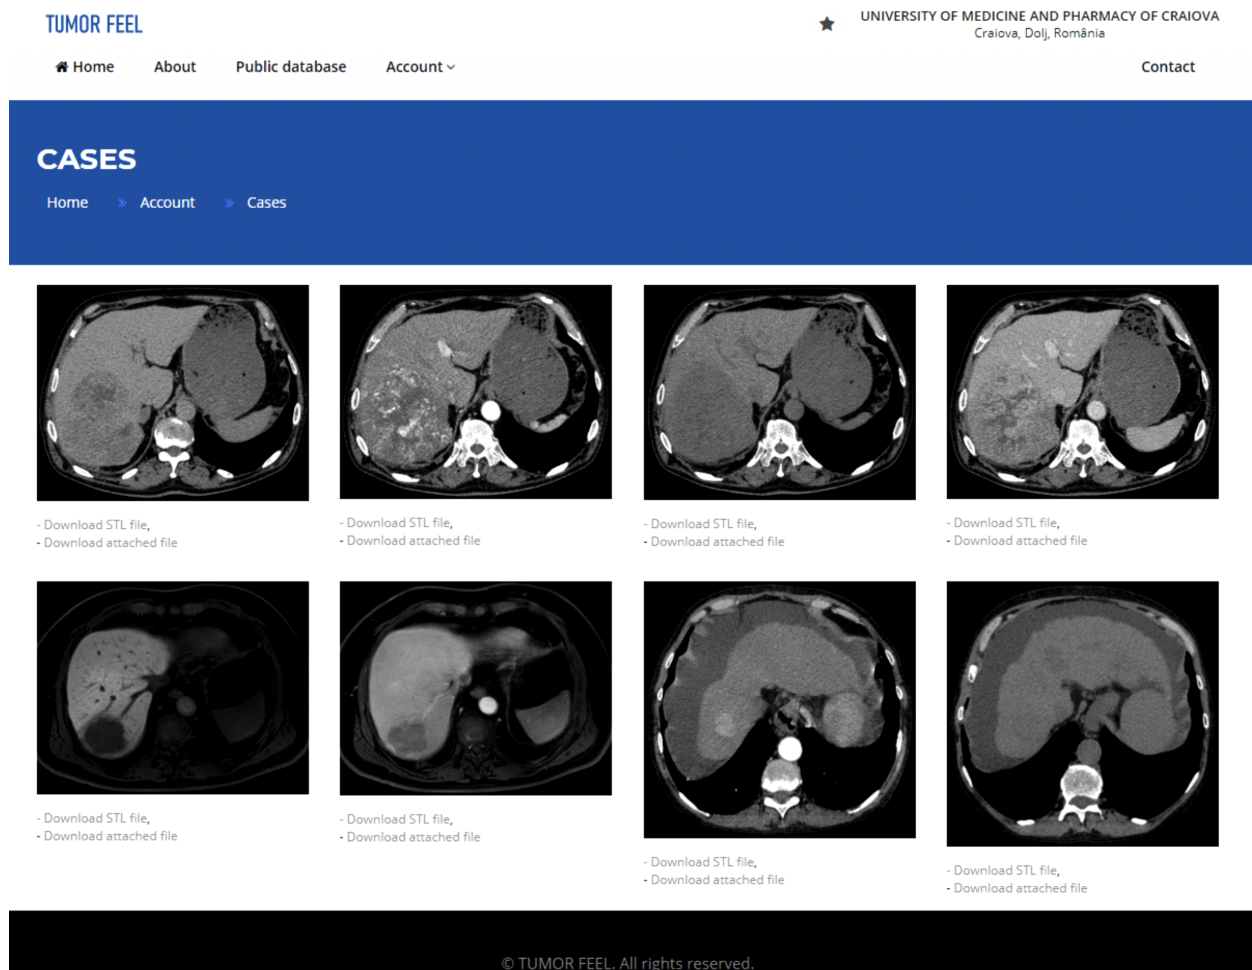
The main screen of the web interface, with CT or MRI images representative for each case. The interface can be accessed after secure login and only designated medical doctors can retrieve data. No identifiable data pertaining to specific patients is stored or displayed at any point. CT: Computed tomography; MRI: Magnetic resonance imaging.
